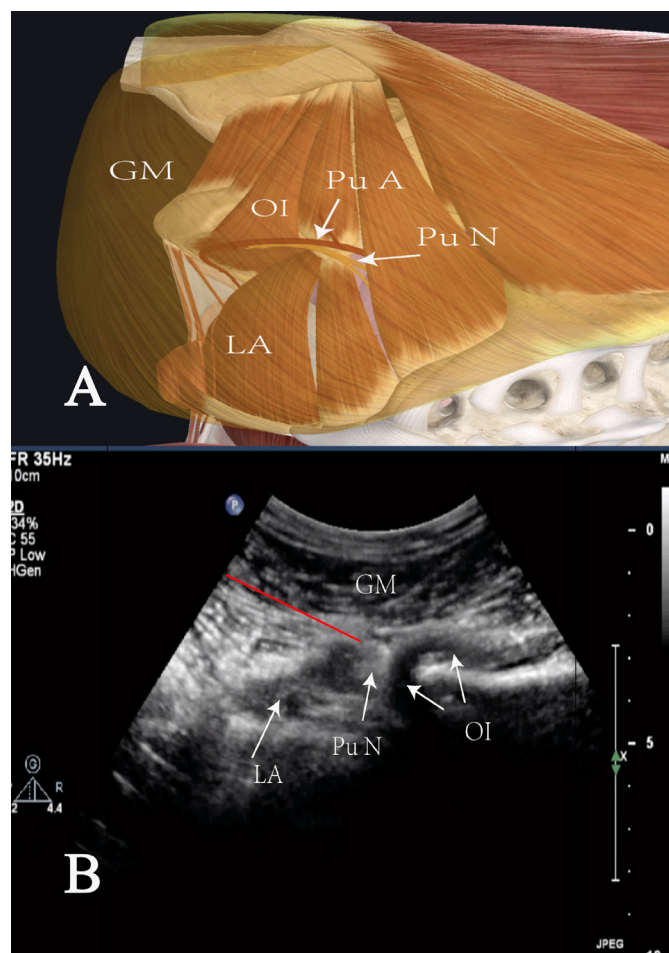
Neuroanatomy and ultrasound imaging of the hips during pudendal nerve block. (A) Topography of the pudendal artery (Pu A) and pudendal nerve (Pu N); and (B) ultrasound depiction of the pudendal nerve. The pudendal nerve is round and hyperechoic. It is located between the gluteus maximus (GM) and the levator ani (LA). Also, note the obturator internus (OI). The red line denotes the needle.
